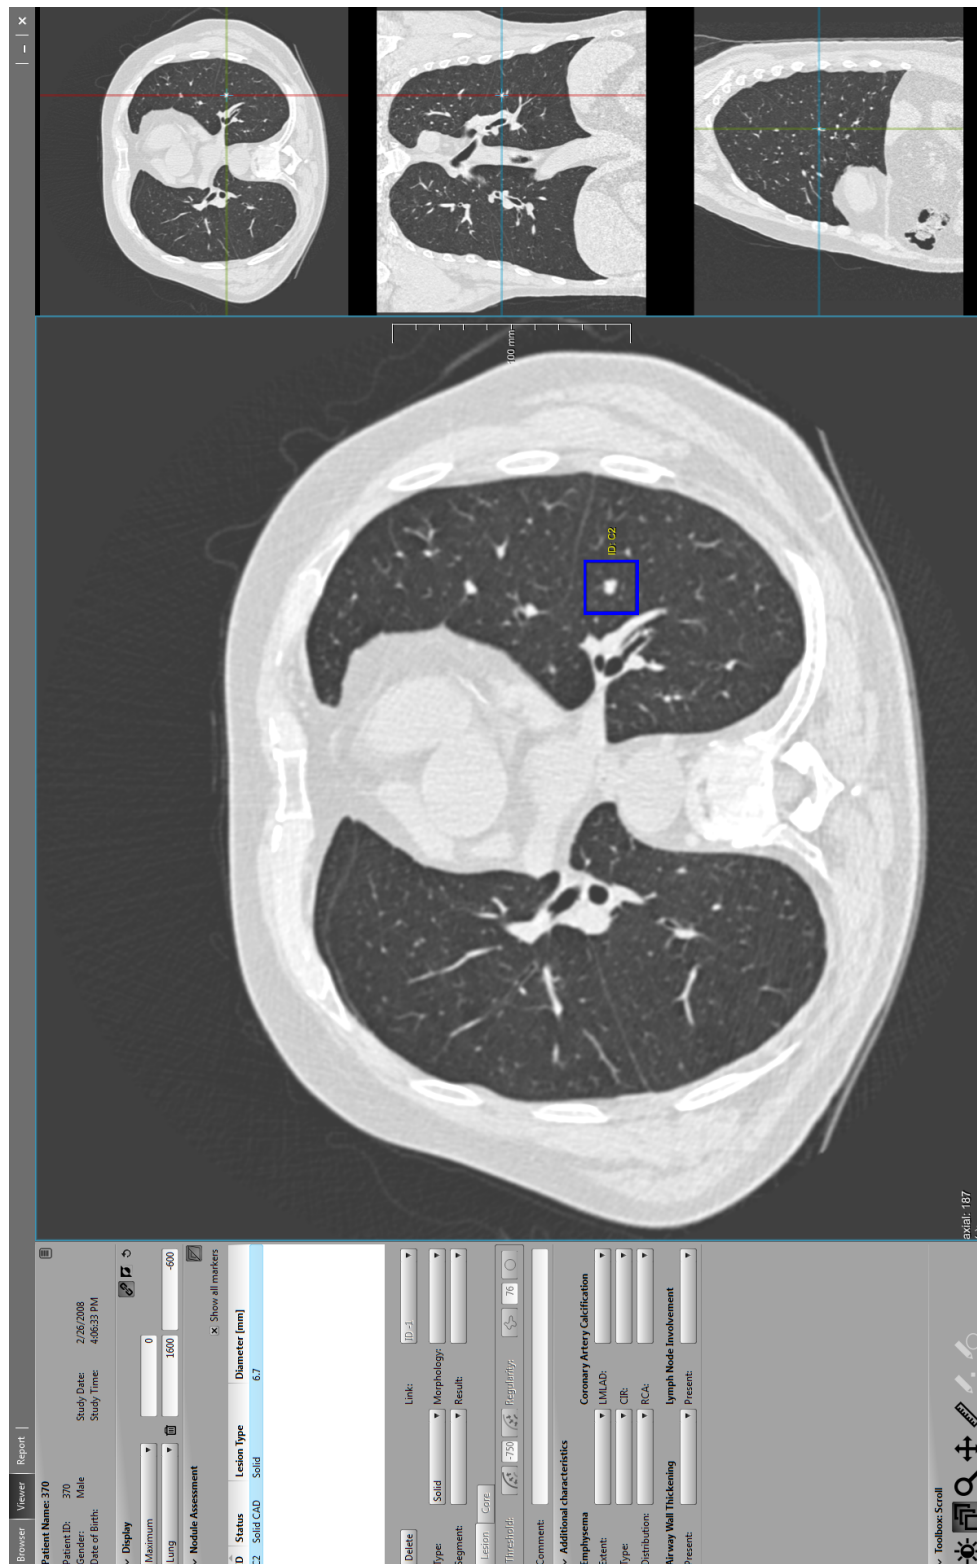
Example of the detection of a new nodule by CAD. Image shows primary screen of workstation, showing the new CT scan acquired in February, 2008. See Fig. 7.3 for second screen.
